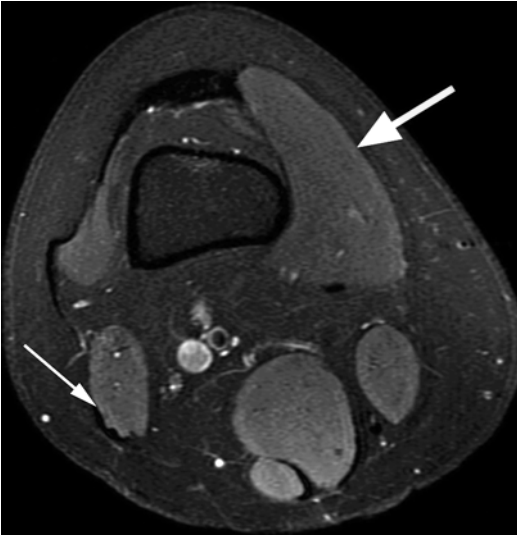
Normal MRI appearance of muscles and tendons in a 33 year old female. Axial proton-density (PD) fat-suppressed image shows the intermediate signal intensity of the muscle (between the signal intensity of fat and cortical bone) (*large arrow* indicating the vastus medialis muscle). The tendons appear as hypointense structures (*small arrow* indicating the tendon of the biceps femoris)
